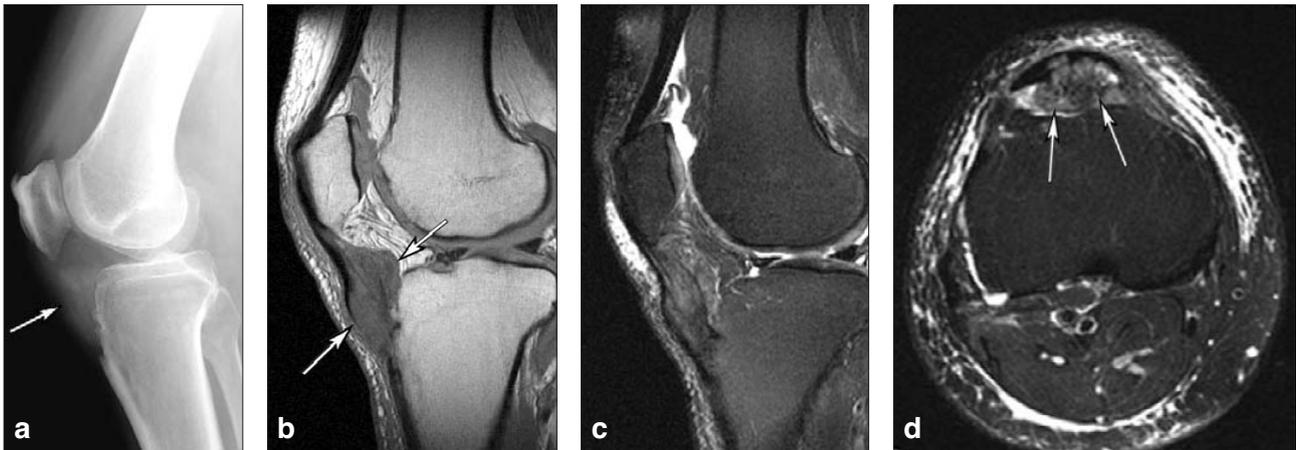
(a) Lateral radiograph of the left knee shows soft tissue fullness inferior to the patella (arrow). (b) T1-weighted sagittal MR image shows a low signal intensity mass infiltrating the entire patellar tendon (arrows). This mass has similar signal intensity as the muscle. (c) Fat suppressed T2-weighted sagittal MR image shows a large heterogenous mass within the patellar tendon. The mass has low to intermediate signal intensity. (d) Axial fat suppressed T2-weighted axial image through the patellar tendon reveals the mass infiltrating the patellar tendon. There is extensive soft tissue edema anterior to the knee. There is also soft tissue edema or fluid between the subcutaneous fat and the superficial fascia posterior to the gastrocnemius muscle.
